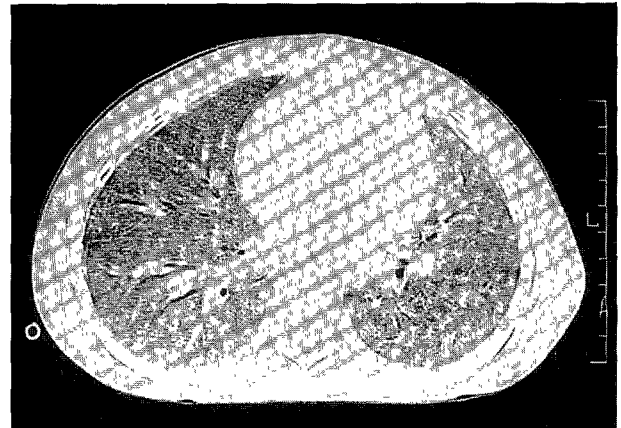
Chest CT scan of case 1 showing bilateral ground-glass opacity.
